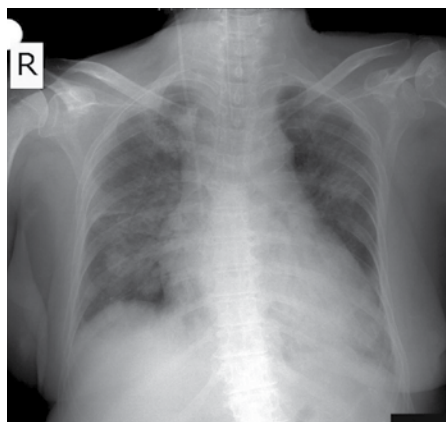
Chest X-ray revealed significant improvement on the second day
